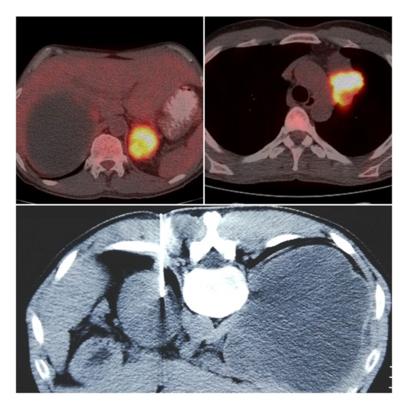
Two cases of transpulmonary approach of a lesion in anterior mediastinum and another in posterior mediastinum with 18g core biopsy needles. In both patients on  $the post biopsy \,CT \,s can \,alveolar \,hae morrhage \,was \,seen \,along \,the \,needle \,pathway. \,The \,first \,case \,was \,a \,SCLC \,and \,the \,second \,was \,inconclusive.$
